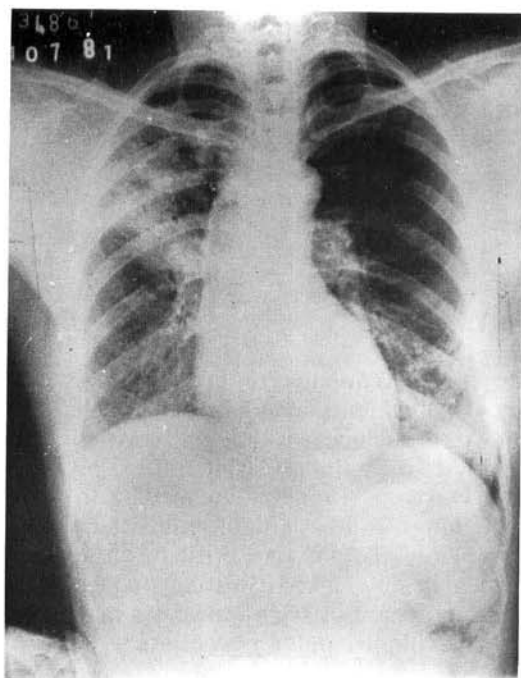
Chest X-ray showing irregular areas with condensation involving the anterior and posterior segments of the right upper lobe.
